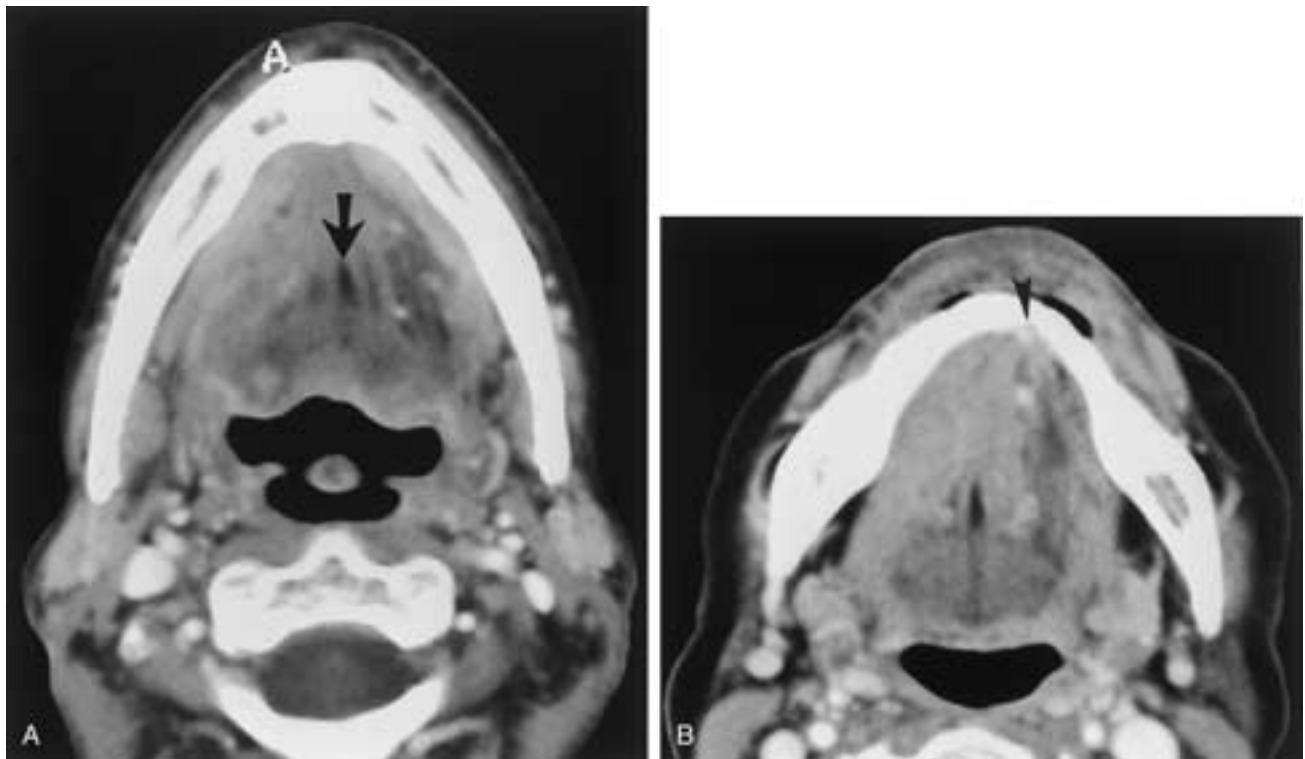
Squamous cell carcinoma of the floor of the mouth in two different patients. Axial contrast-enhanced CT scans in patients 1 (A) and 2 (B) demonstrate poorly defined masses in the right floor of the mouth obliterating the right sublingual space fat. In A there appears to be involvement of the right genioglossus muscle with midline displacement (*arrow*), while in B there is involvement of both genioglossus muscles as well as cortical mandibular erosion (*arrowhead*).
